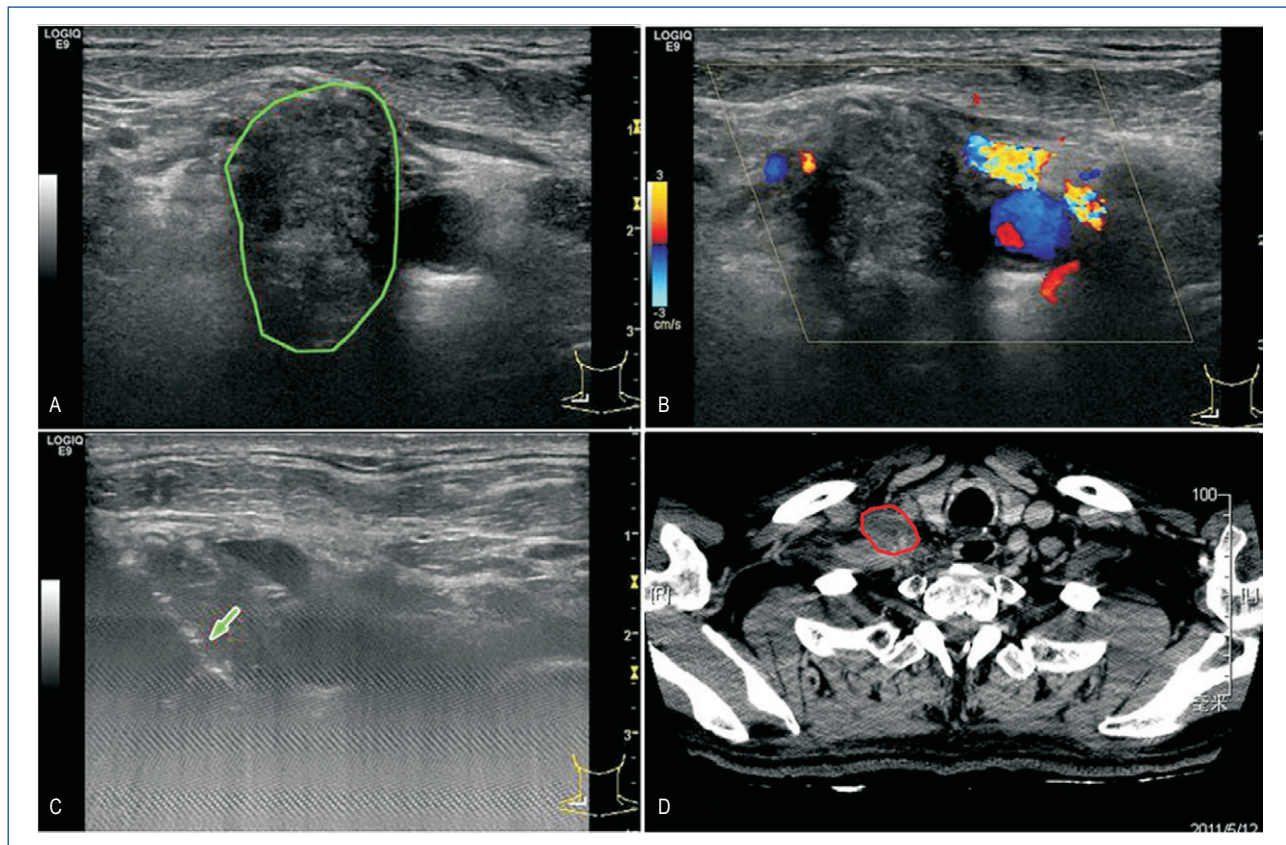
Radiofrequency ablation of lymph node metastasis in a 57-year-old woman with esophageal carcinoma. A, ultrasound image shows lymph node metastasis (inside the green circle). B, the internal jugular vein (mixture of yellow and blue) and the common carotid artery (blue) are located on the inner side of the lymph node. C, a radiofrequency needle (green arrow) was punctured into the lymph node. D, the treated lymph node was not enhanced on CT scan (red circle).
